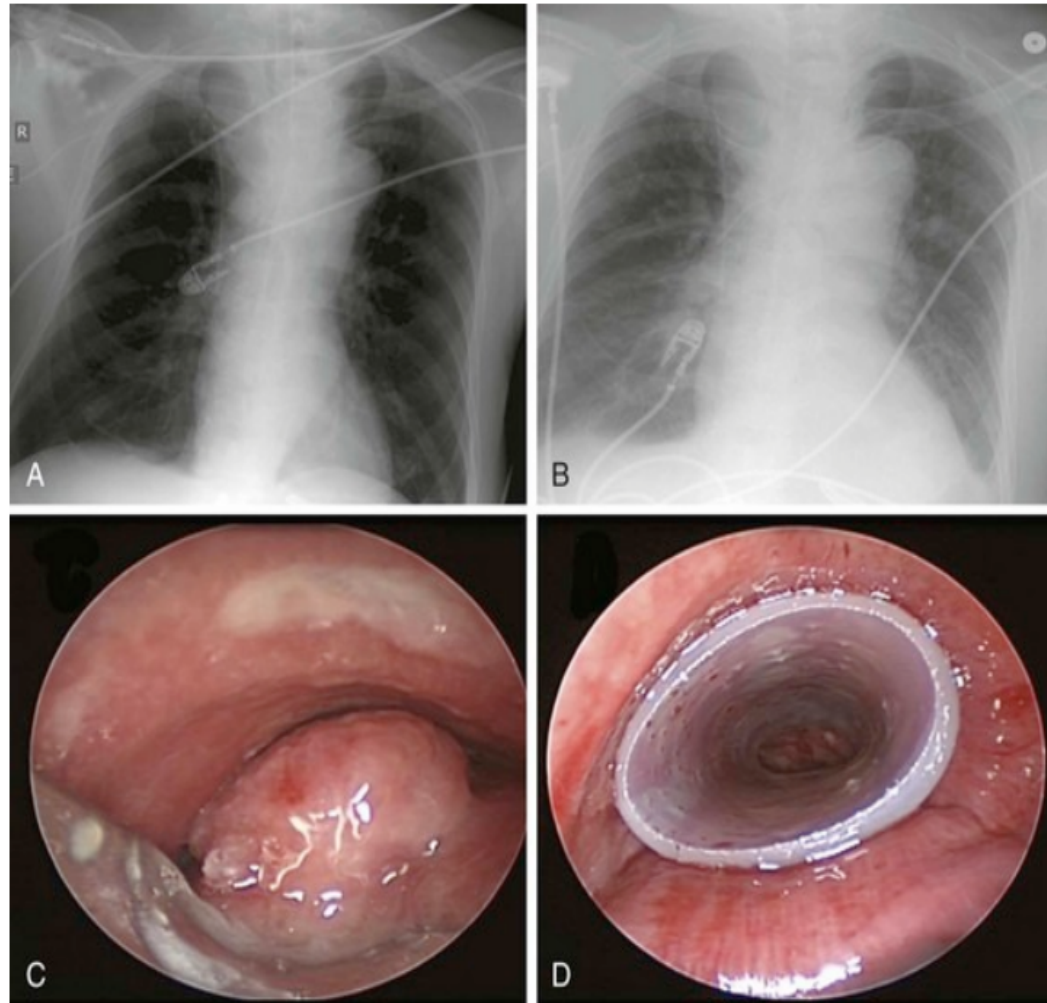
A, Chest x-ray (CXR) before the bronchoscopy showed a soft tissue mass density projecting to the right of the trachea, enlarged lung volumes bilaterally, and the endotracheal tube (ETT). B, The day after the rigid bronchoscopy, the ETT was removed, and air trapping had resolved. C, Rigid bronchoscopic view of the mixed airway obstruction, which consisted of exophytic endoluminal mass and extrinsic compression. D, Indwelling silicone stent after rigid bronchoscopy restored airway patency but is still partially compressed in the anteroposterior diameter.
